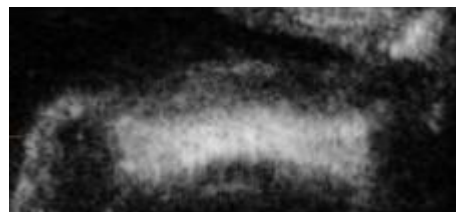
19 (left column) and 34 (right column) weeks 3D ultrasound views. Top row represents the axial (transverse) plane. Mid row represents the sagittal (longitudinal) plane. Bottom row represents the coronal plane.
